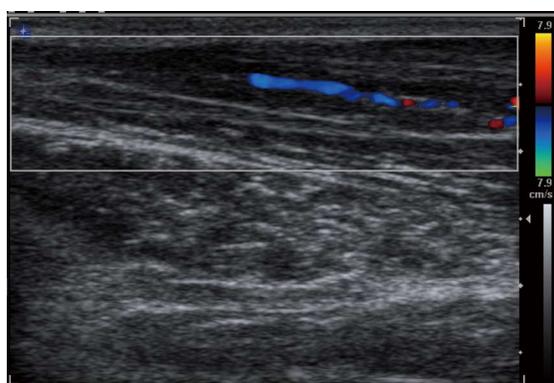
Longitudinal color Doppler sonogram in a 40-year-old woman with severe carpal tunnel syndrome shows intraneural hypervascularity in the median nerve.
